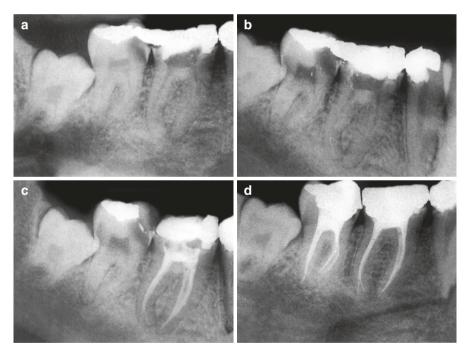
(a) Preoperative radiograph. (b) Fractured instrument in the apical third of the curved distal root of a first mandibular molar. (c) Root perforation and creation of "iatrogenic" canal during unsuccessful efforts to retrieve or bypass the fragment with the file bypass technique. Immediate post-obturation radiograph. Note gutta-percha in the artificially created canal and separated instrument still in place. (d) Three-year recall radiograph showing complete healing (with permission from Lambrianidis 2001)
